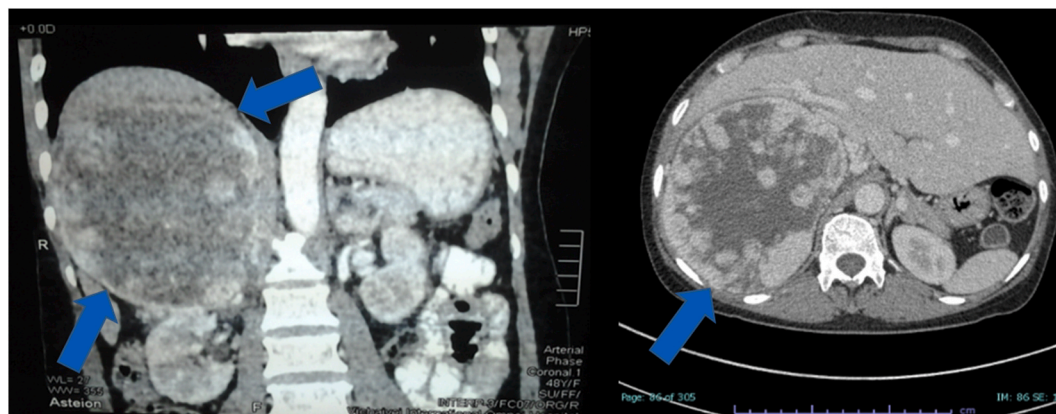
CT scan of the abdomen in the coronal and axial planes show a large right suprarenal mass 9.9 × 12.7 × 14.7 cm with central necrosis (arrow). The mass was exerting pressure on the liver, inferior vena cava, and right renal vein. There was no definite evidence of intraabdominal metastasis.
